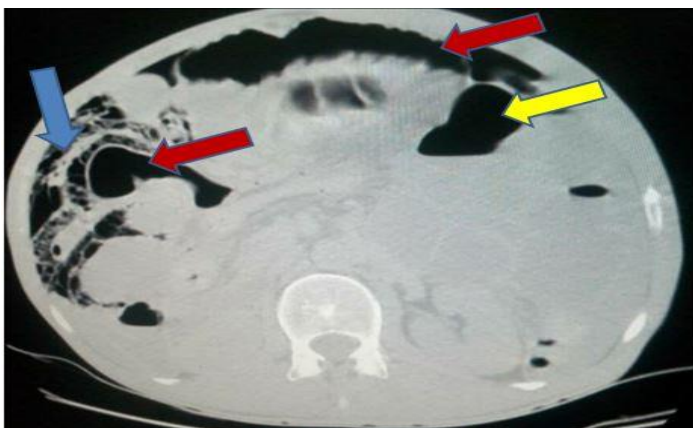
Abdominal computed tomography of the patient. Blue arrow: Suspicion of parietal pneumatosis, red arrow: gas in the small intestine, yellow arrow: hydro-aeric level colic type
